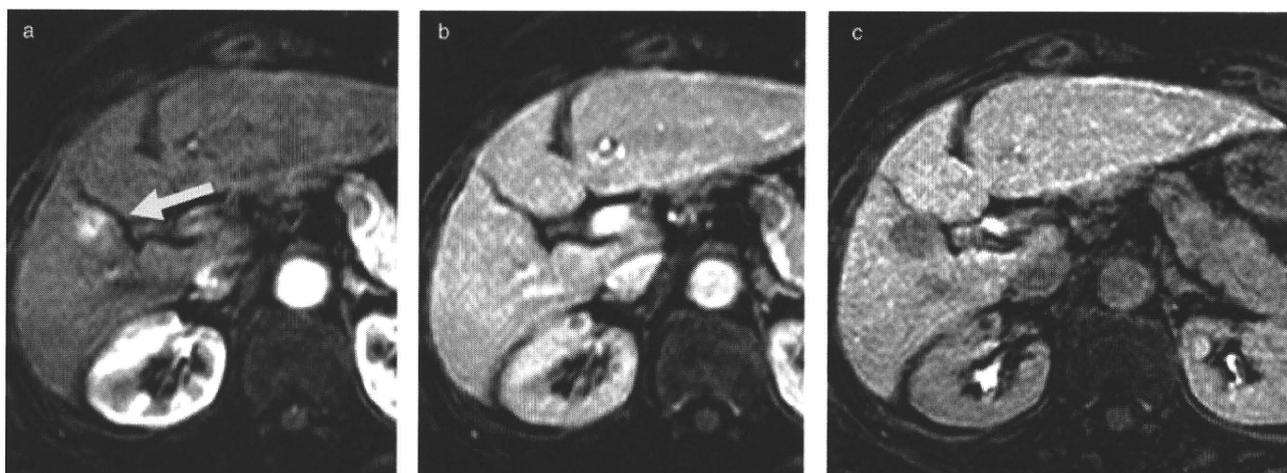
Typical findings of hepatocellular carcinoma (HCC) on Gd-EOB-DTPA magnetic resonance imaging (MRI). (a) Arterial enhancement (arrow) is evident on arterial phase. (b) Slight washout is seen on portal phase. (c) Clean defect is seen on hepatocyte specific phase 20 min later.
